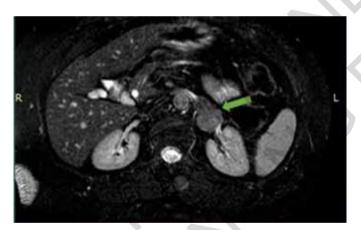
MRI showed a solid mass on the left side between the adrenal gland and upper renal pole.
